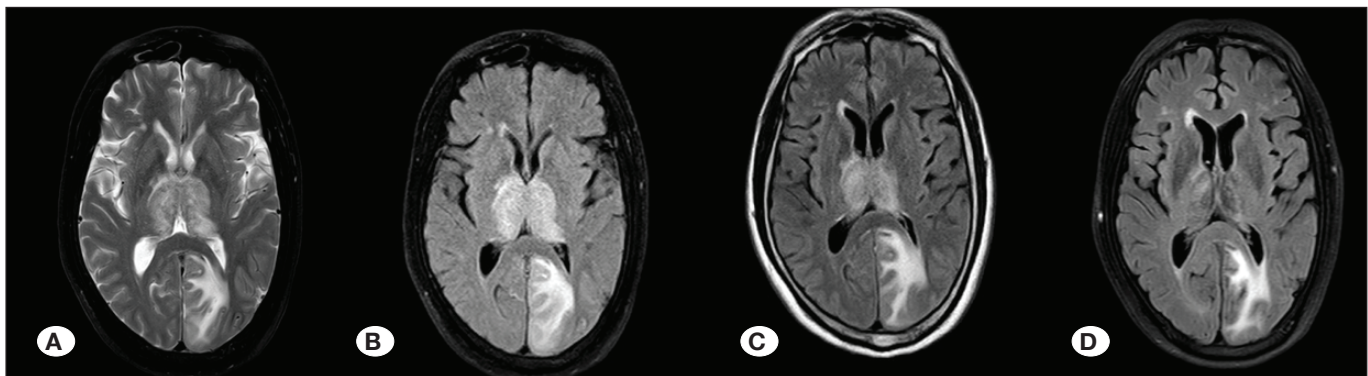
MRI A) T2-weighted axial and B) FLAIR demonstrating bilateral thalamic and left parietal lobe hyperintensity with minimal mass effect. Note the “butterfly” appearance suggesting a lesion crossing the midline through the interthalamic adhesion. C) FLAIR demonstrating bilateral thalamic and left parietal lobe hyperintensity reducing after postoperative one day. D) Images obtained 3 weeks after endovascular embolization of DAVF. FLAIR MRI showing resolution of bi-thalamic hyperintensities.
